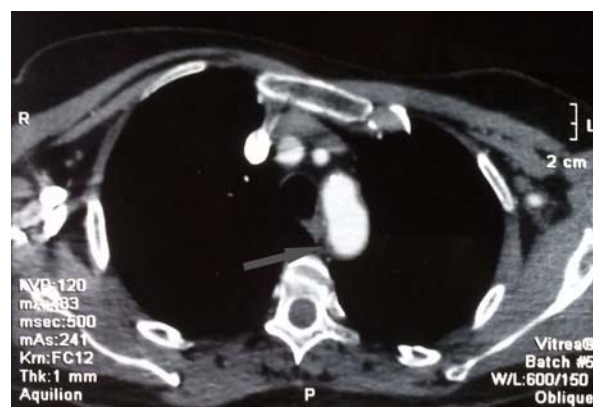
Multislice computed tomography (MSCT) aortography shows slight aortic arch atheromatosis with thickening of the thoracic aorta wall.
